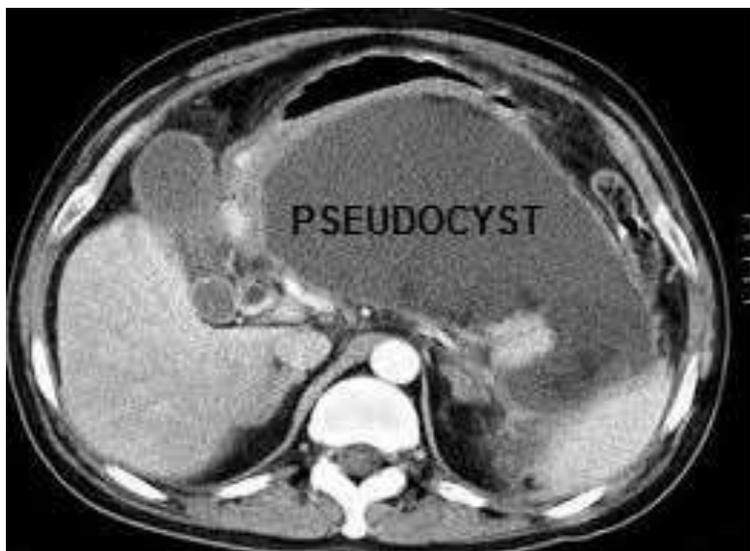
Pseudocyst of pancreas in CT scan
